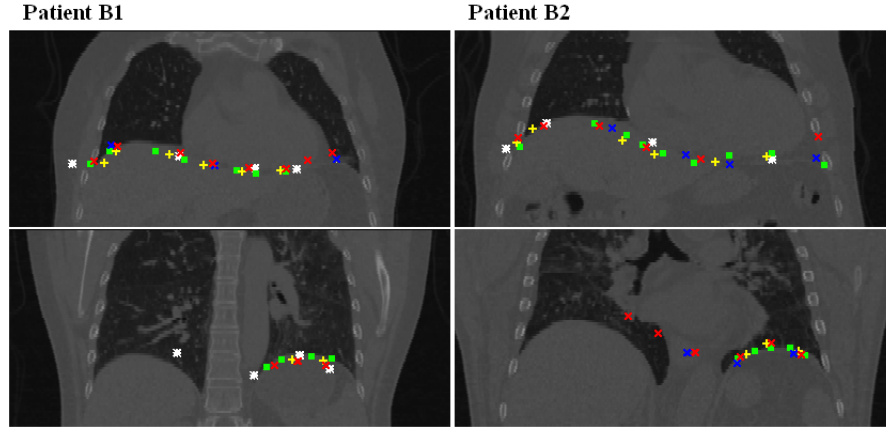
Coronal slices showing the PET landmarks identified by the two users, overlaid on the corresponding CT slices. While many of the landmarks were placed on or close to the diaphragm, some exhibit larger errors and regions exist in which there are few or no landmarks. These correspond with the poor contrast regions in PET.
